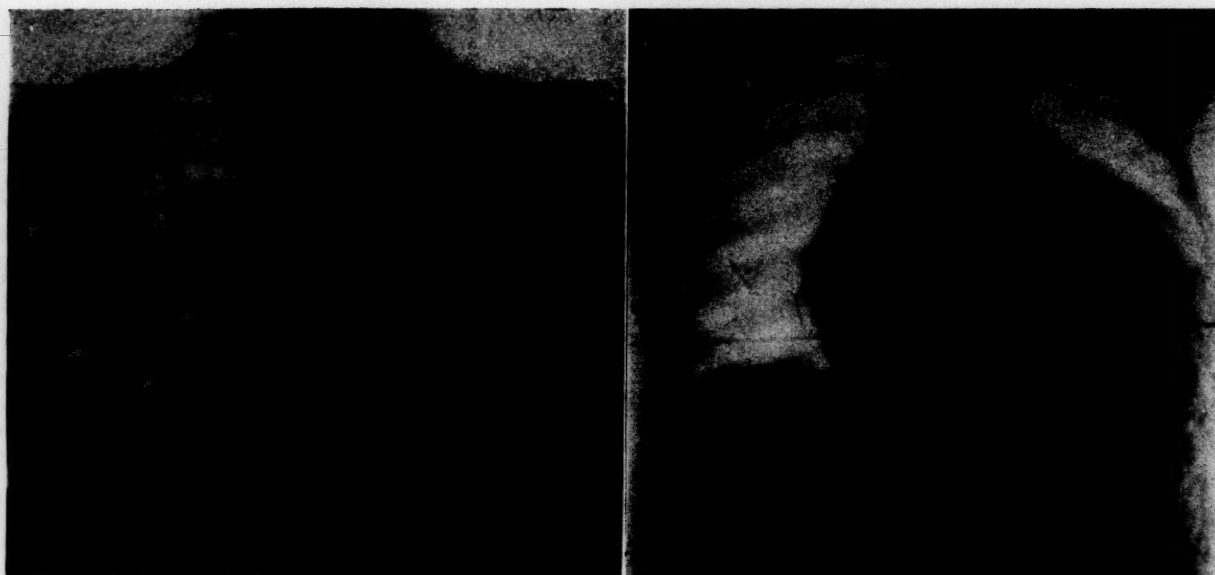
Huge heart in pure pulmonary valvular stenosis in a child aged seven years. In the plain radiograph the dilated pulmonary artery is concealed by the huge heart but is revealed in the angiogram.
